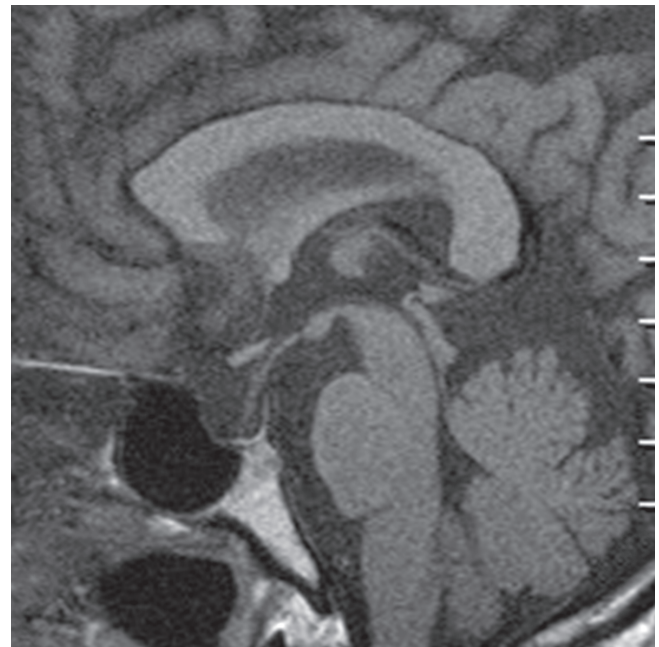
The sagittal noncontrast T1 weighted magnetic resonance image of the brain shows an enlarged sella turcica and a nonvisualized gland.
